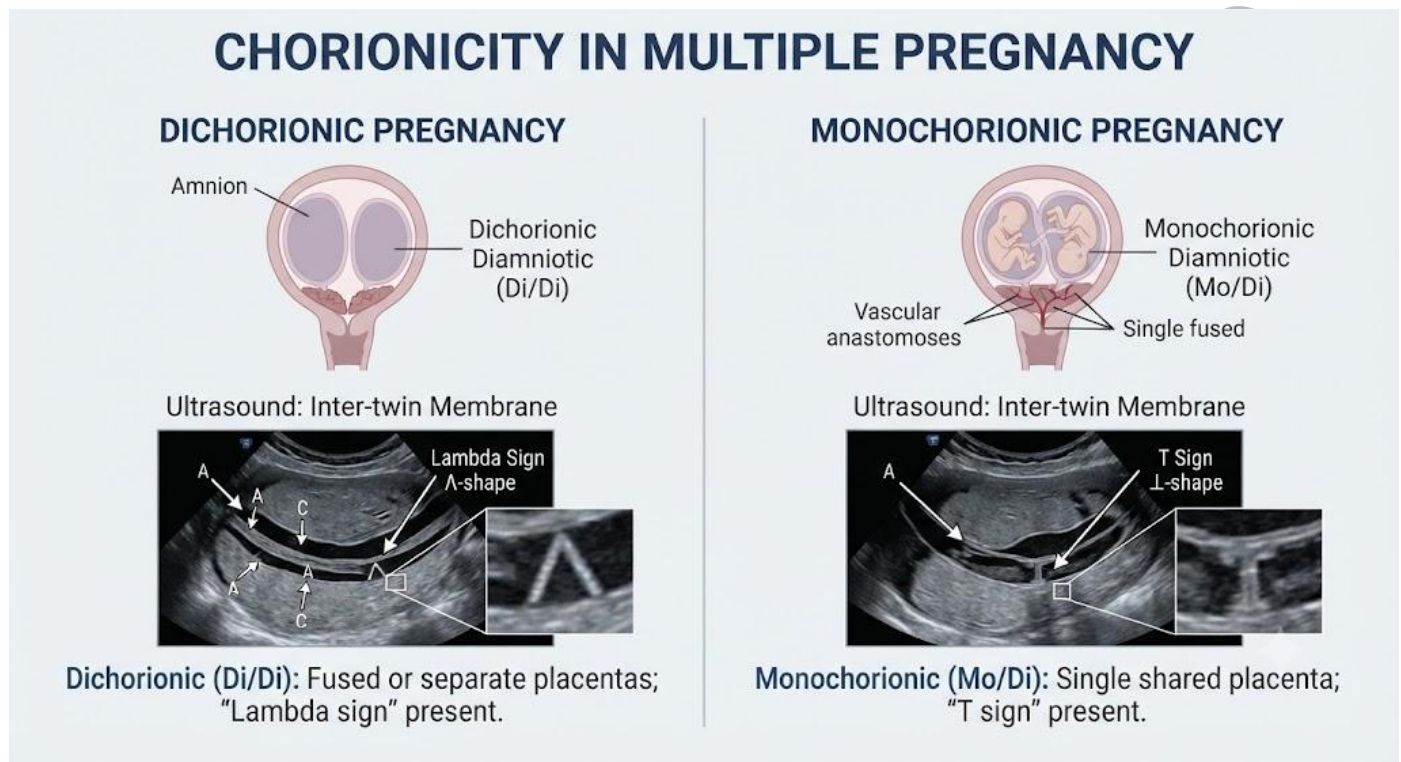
Chorionicity patterns in multiple pregnancy and their ultrasound identification.
